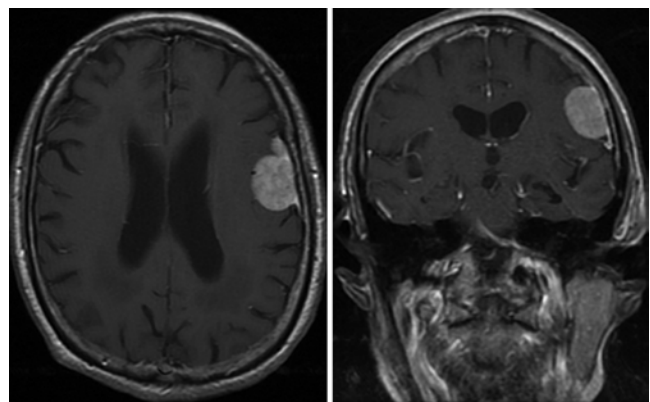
Axial (left) and coronal (right) contrast-enhanced T1-weighted MR images obtained in a 93-year-old woman who presented with a 2-week history of severe headaches. The images demonstrate a left frontal meningioma. The headaches resolved spontaneously and no treatment was recommended.
